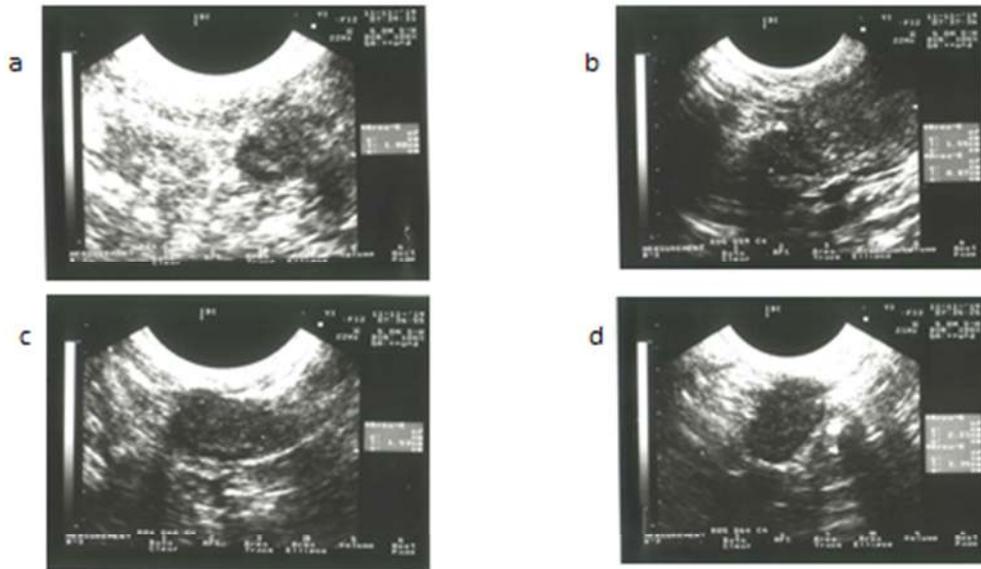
Ultrasound images for OD-D female. a and b showed right ovary with measurement about 1X0.87 cm. b and d for the left ovary, which is 2.21X1.35cm .
